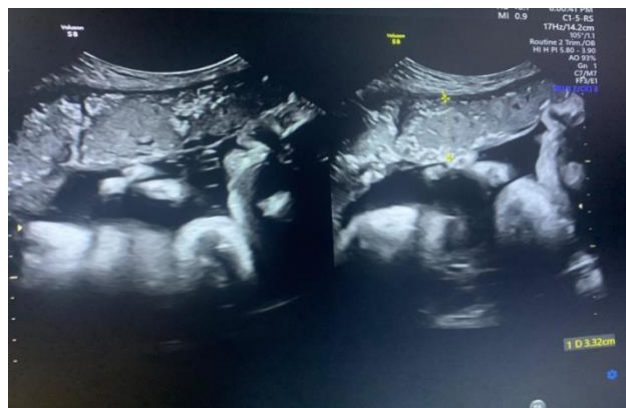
ultrasound image of 39 weeks gestational age , with maturity grade III and placental thickness (33.2 mm) , the EFW was 3000 gm
